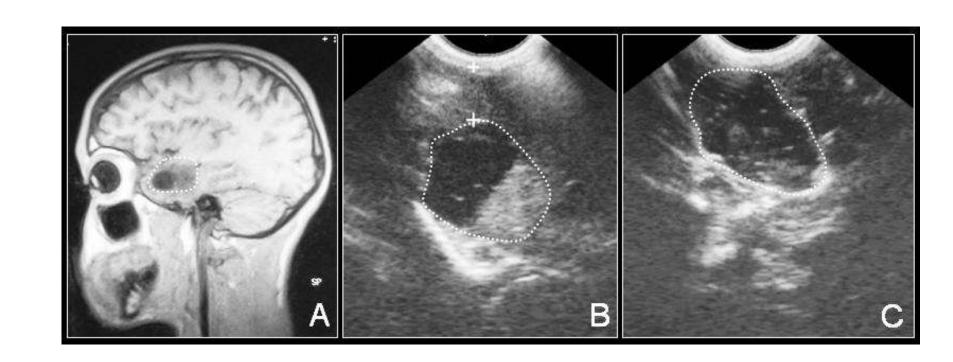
(A) The sagital MRI scan of a low grade glioma, showing a uniformly hypointense mass with a cyst in the temporal lobe with well defined margins. (B) The axial IOUS done soon after opening the dura. Note the hyperechoic tumour with well-defined margins. (C) IOUS after complete removal of tumor.
